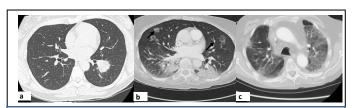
(a,b,c): axial computed tomography scans showing COP in patient with sarcoma presenting as a mass mimicking the underlying cancer, 2b- atoll sign -central area of ground-glass opacity surrounded completely or partially by a ring or crescent of consolidation (arrow), 2c - diffuse infiltrative lung disease with reticular and superimposed alveolar opacities .
